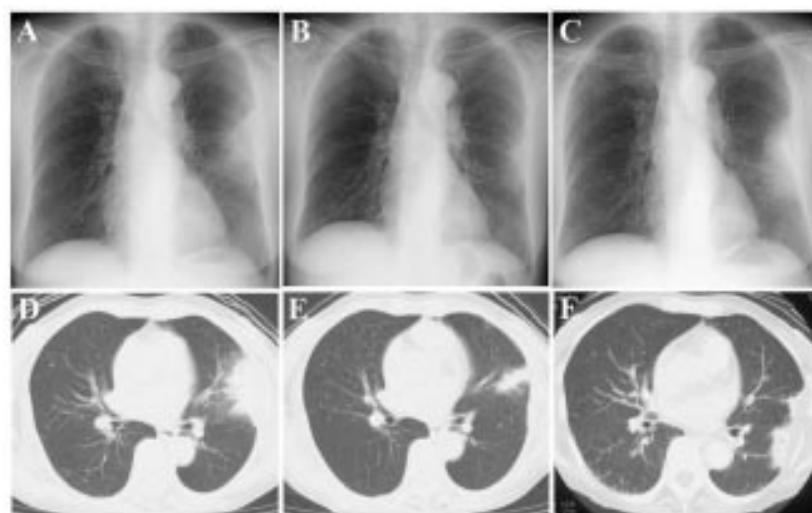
Chest radiograph and CT scan on first admission (A, D), at partial improvement (B, E), and on second admission (C, F) showing deterioration and improvement of a fan shaped patchy shadow on the pleura.
